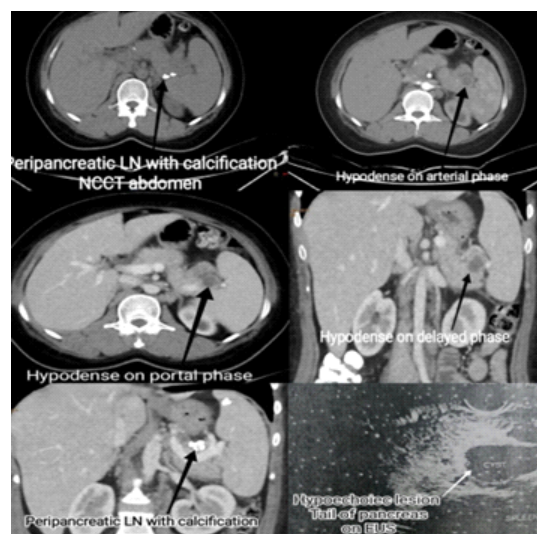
Contrast-enhanced computed Tomography and Endoscopic Ultrasonographic images of Pancreatic tuberculosis mass. (A) Non-contrast images show Peri-pancreatic Lymph node calcification and a hypodense lesion in the tail of the pancreas, which is seen in all the phases (B, C, D). The image shows Peripancreatic Lymph node calcification in a Coronal Section. Image (F) reveals an EUS finding of a hypoechoic lesion in the tail of the pancreas.
